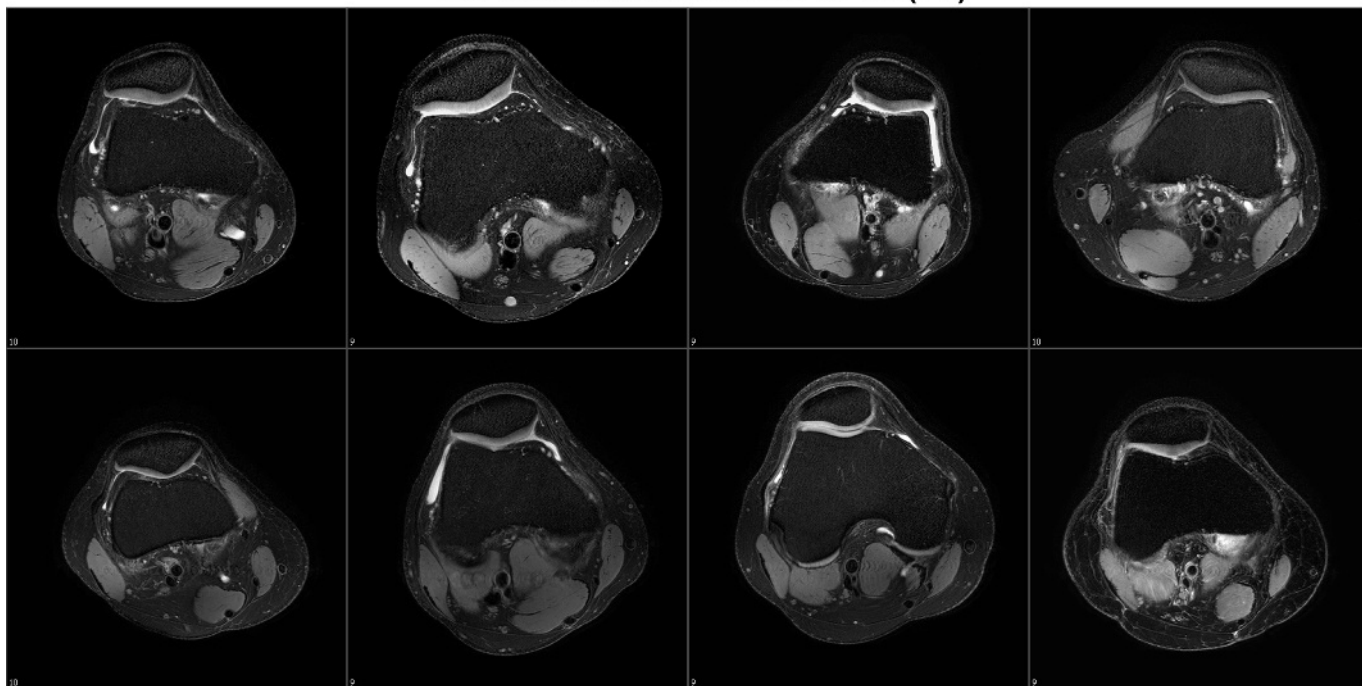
Series of axial MRI scans of all 8 volunteers shows the consistency of the SSGR + SPIR technique for the whole cohort at 7 T for the whole cohort.
